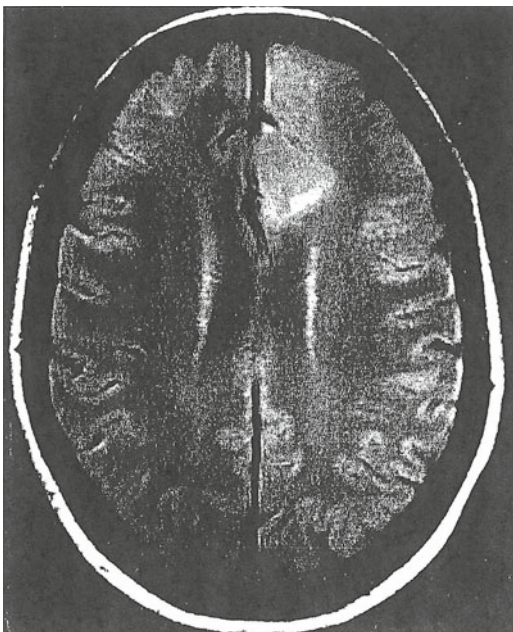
Axial CT frontal lobe scan in a patient with cavernous angioma and intractable epilepsy. Published in Crespel, A., et al. *Atlas of electroencephalography Volume 2: The Epilepsies, EEG and Epileptic syndromes*. With permission of John Libbey Eurotext
